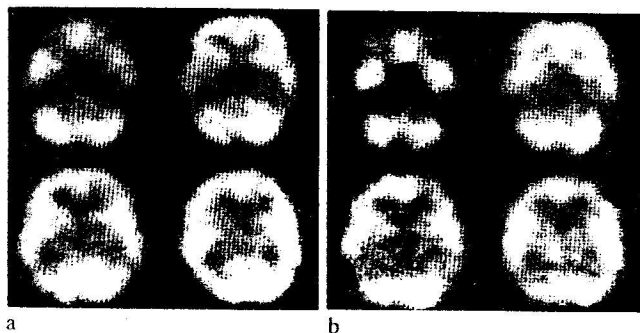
SPECT in non-herpetic encephalitis. *Case 9* in the Table imaged with HM-PAO. a) SPECT 10 days after first symptoms of encephalitis. No perfusion abnormalities are present. b) SPECT 193 days after onset. No hyperperfusion or other abnormalities present.
